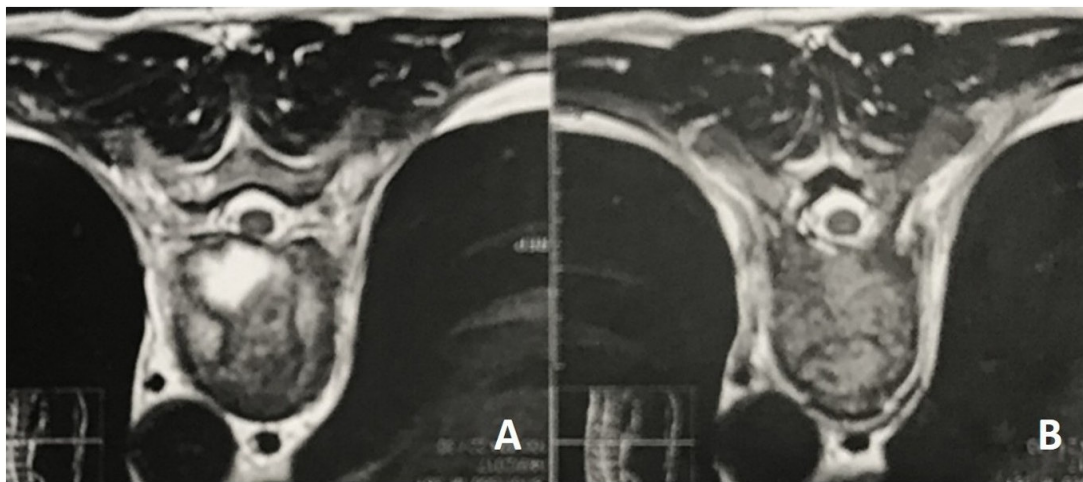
A-B. Axial MRI showing involvement of the T8 vertebral body.
